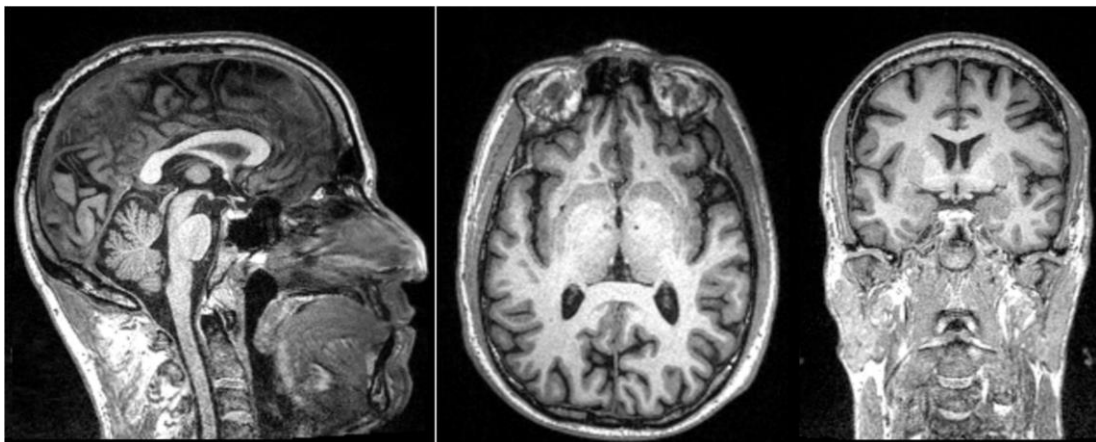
The sagittal, axial, and coronal view of an MRI from the left to the right.
